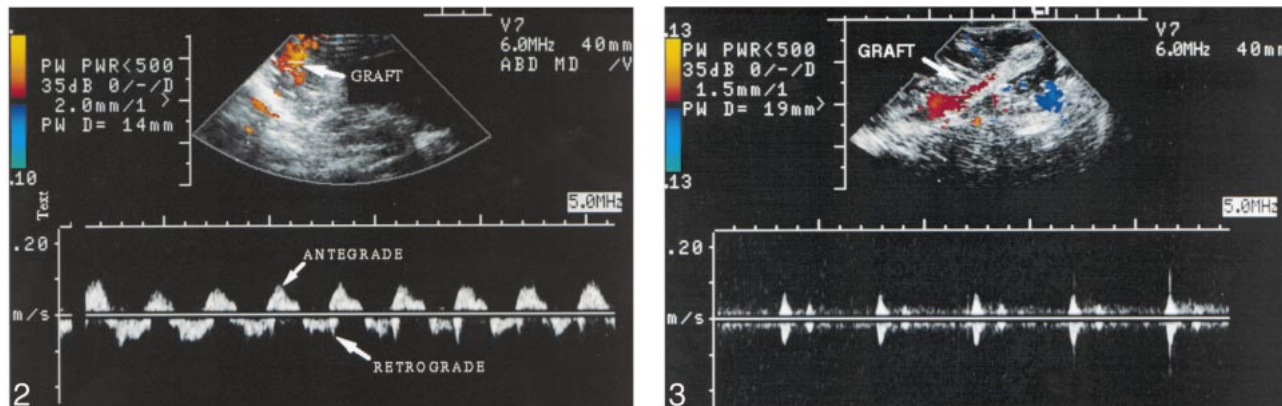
Color and pulsed Doppler sonographic image obtained during superficial temporal artery bypass surgery. The anatomic structure coded in *red* is the superficial temporal artery just proximal to the anastomosis. Portions of the waveform above the baseline represent flow toward the transducer (antegrade), whereas portions below the baseline represent flow away from the transducer (retrograde). Note the slow, bidirectional ("to-and-fro") flow, which implies sequential perfusion of the graft from different circulations.
